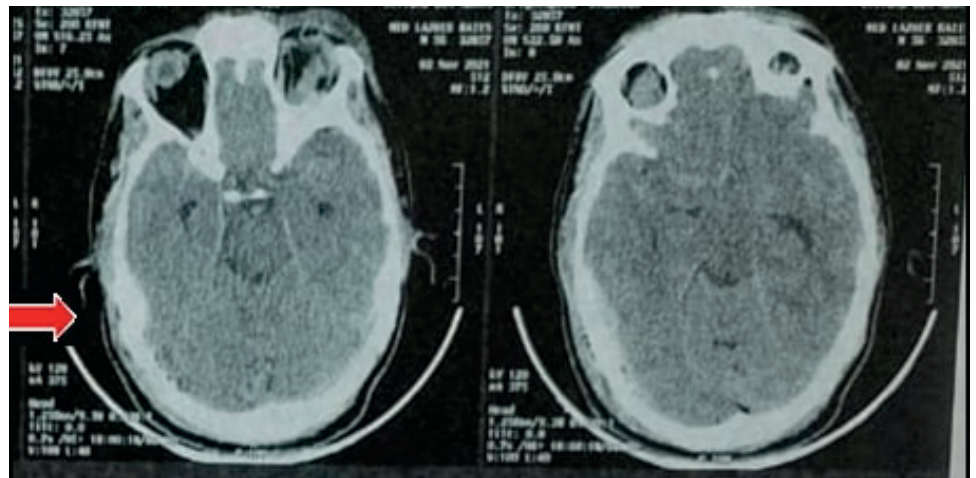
Axial section of a brain computed tomography scan showing an occipital fracture displacement regarding transverse sinus (red arrow).
